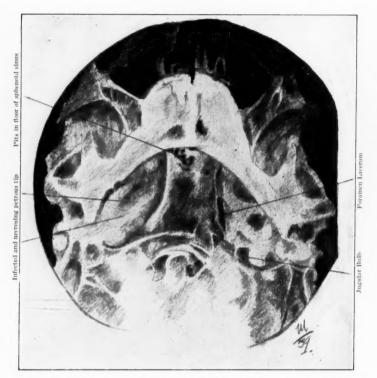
Mulvey. Tracing of an x-ray film. On the left it shows marked fogging of the petrous tip. Everything in the basal fossa of the tip is blurred, especially the foramen lacerum. On the right the edges of the bony markings are clear cut. The foramen lacerum stands out distinctly. At the upper part of the basilar process there appear to be a number of erosions on the pharyngeal surface. A repeat x-ray which showed more of the sphenoidal sinus, in fact the greater part of it, made it clear that these apparent erosions were irregularities or pits in the bottom of the sinus. At first the writer considered them osteomyelitic erosions. This was an example of wishful thinking which was fortunately corrected in time. (See Fig. 24.)
